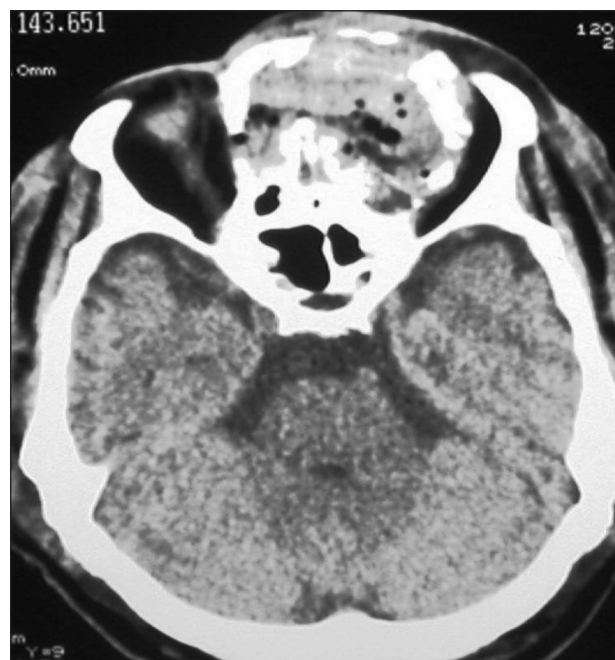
CT scan shows the etmoidal part of the tumor.
